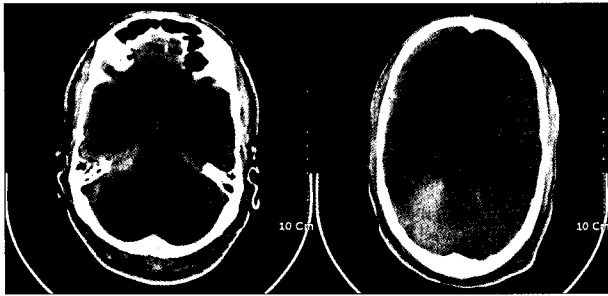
Brain computed tomography at admission showing acute subdural hematoma at right fronto-temporo-parietal area and tentorium, with compressing mild ipsilateral ventricle.
